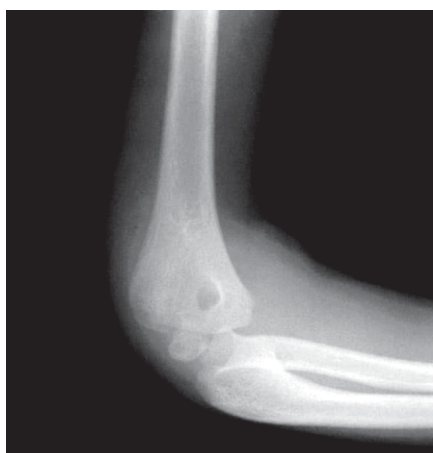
Showing internal oblique radiographic view
